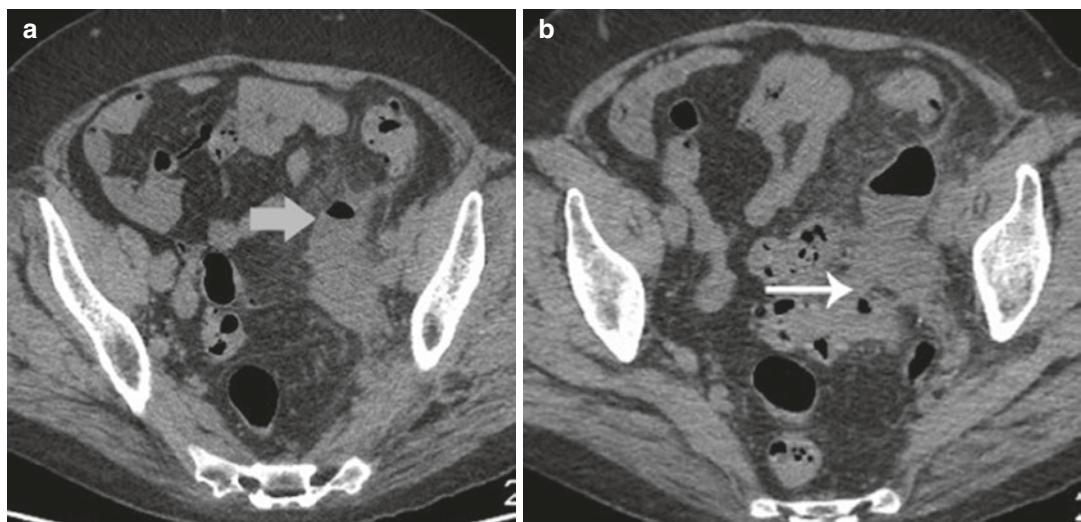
(a) Non-enhanced axial CT image of the pelvis without contrast in a 66-year-old woman with left lower quadrant pain showing an area of inflammation in the area of the sigmoid colon related to focal diverticulitis (white arrow). (b) A second axial image at a slightly lower level demonstrates an air-fluid level (gray arrow) denoting an abscess in the left ovary. This was a sequela of direct communication with the perforated sigmoid diverticulitis
